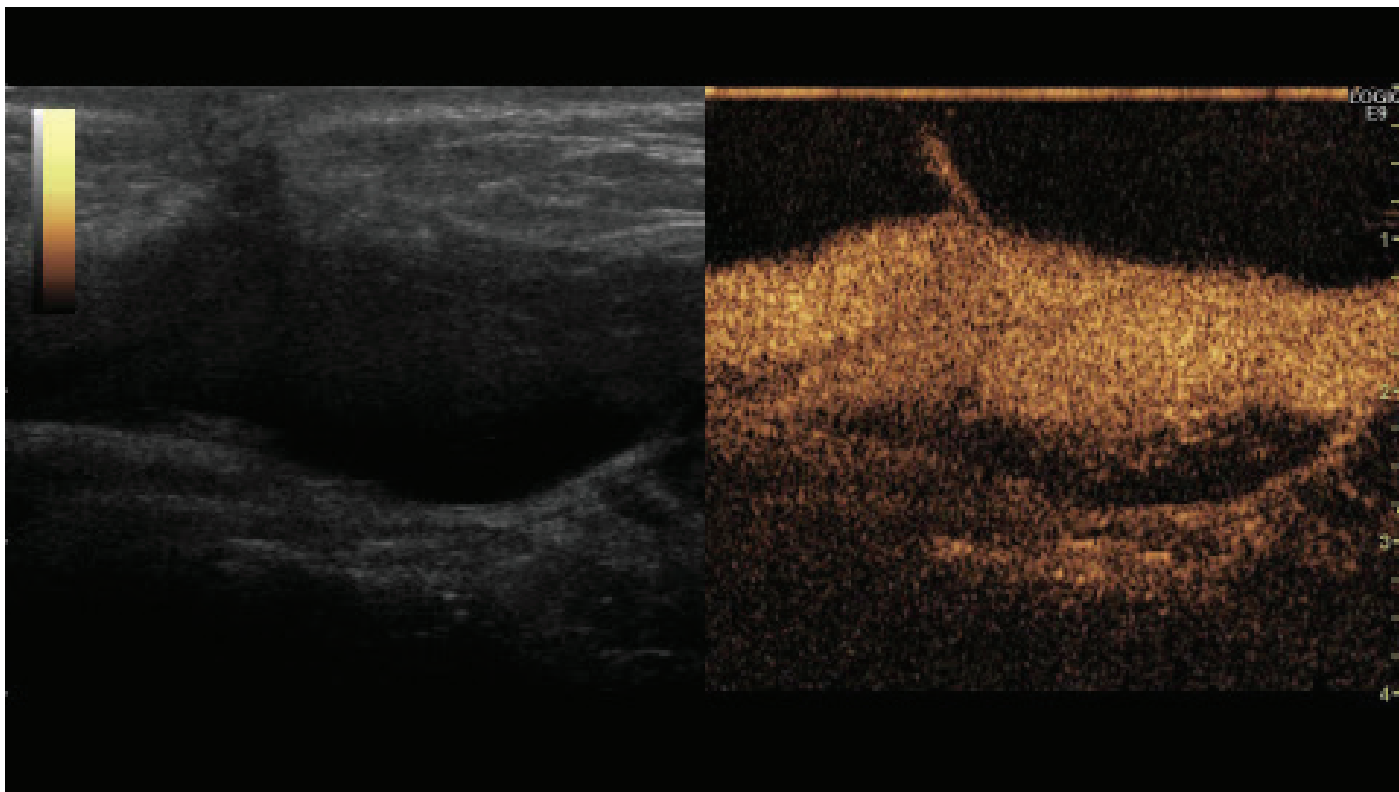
Contrast enhanced ultrasound fistulography ultrasound image of a contrast enhanced ultrasound examination of a fluid collection in the abdominal wall obtained with simultaneous dual display technique. The picture to the left is a fundamental i.e. “normal” ultrasound scan and the picture to the right is a second harmonic scan obtained at the exact same place and time. Both scans are obtained using low mechanical index setting to avoid bursting the bubbles in the contrast agent, which accounts for the darker than usual appearance. The abdominal wall fluid collection communicates to the skin via a narrow fistula and ultrasound contrast agent Sonovue[®] has been injected in the skin opening. Because Sonovue[®] is the only source in the image plane to give rise to second harmonic signals the contrast agent stands out clearly visualised on the dark background of tissue without signals. The subcutaneous fistula and the fluid collection itself are easily depicted in the harmonic image with its content of bright contrast agent whereas in the fundamental image the fistula cannot be differentiated from its surrounding oedematous tissue.
